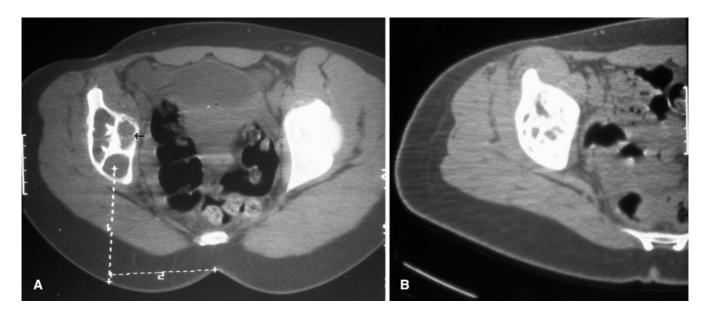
Preoperative CT scan showing an aneurysmal bone cyst of the ilium with fluid-on-fluid levels. B Eighteen months after the second Ethibloc injection showing endosteal new bone formation with nonprogressive residual lytic areas
